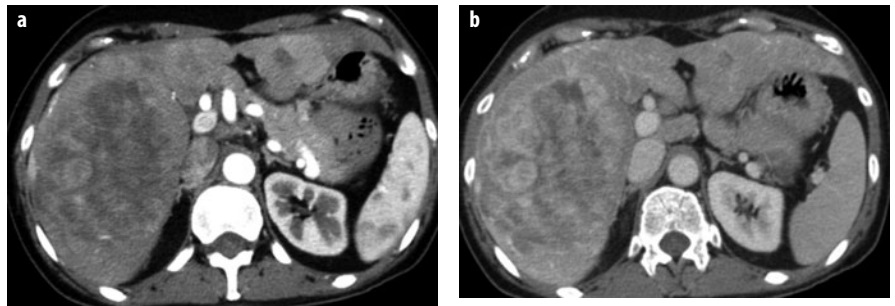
a, b. HCA, inflammatory type. a Arterial-phase CT shows strong and progressive contrast enhancement, which is retained in the b delayed phase and is typical for peliotic changes in inflammatory adenoma
